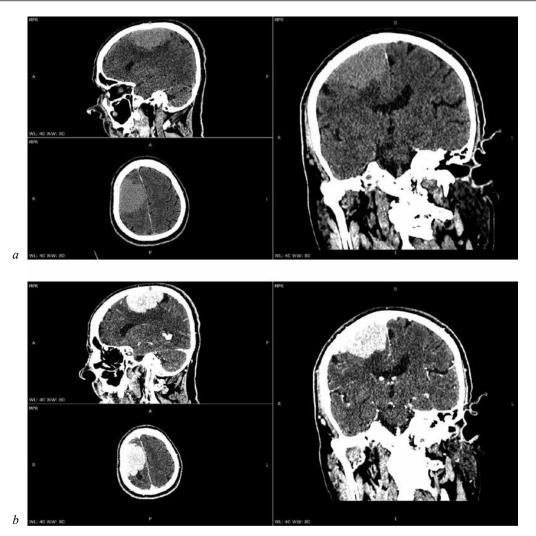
Computed tomography of the patient's brain: a – without contrast enhancement; b – with contrast enhancement
